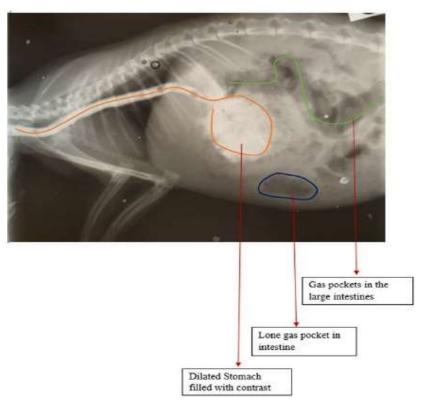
Contrast Radiograph showing early images of upper gastrointestinal tract (Left lateral view). Source: Author 2022
